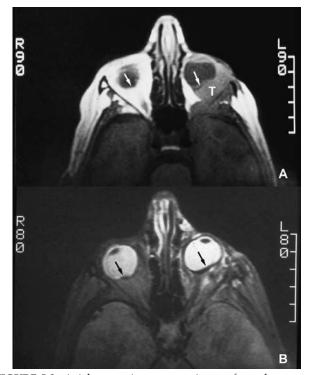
Axial magnetic resonance images from the same patient depicting the osteogenic sarcoma (T) compressing onto the left globe; arrows indicate remnants of calcified Rb. (A) T1-weighted image. (B) T2-weighted image.
